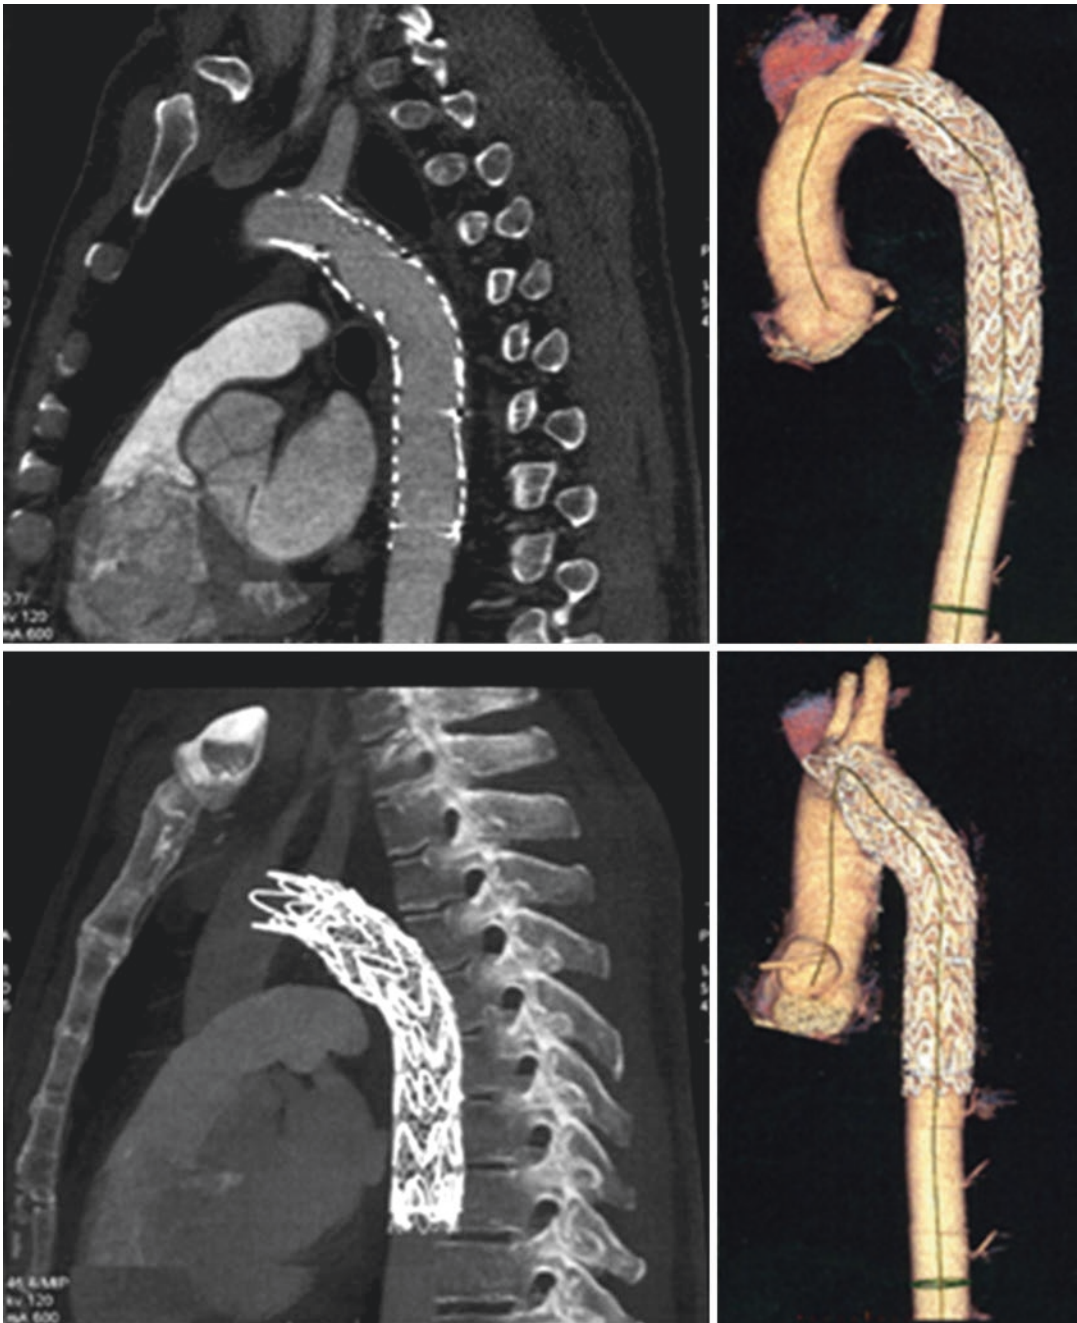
Postoperative CT scan of TEVAR graft properly positioned in thoracic aorta; left subclavian artery is patent (reproduced from Nano et al., *J Cardiothorac Surg* 2011) [25]
